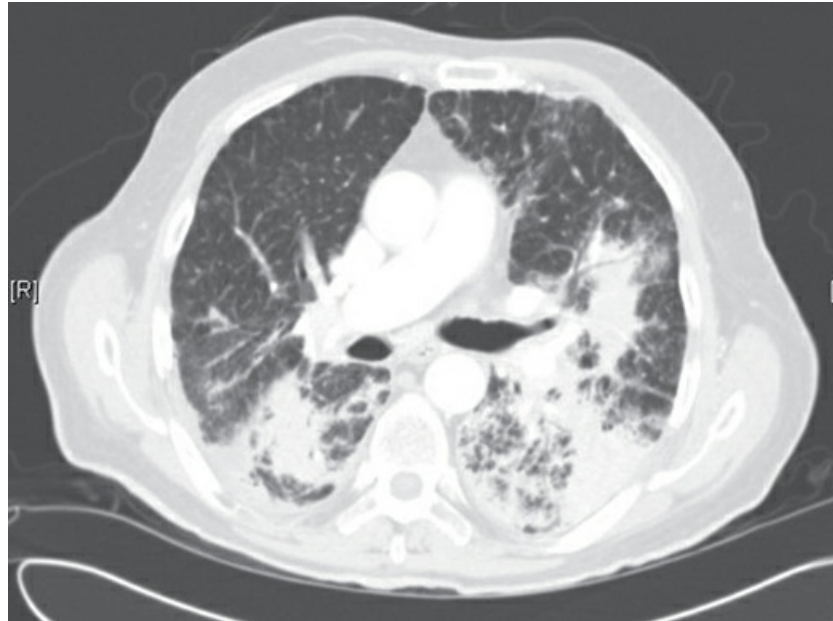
Chest CT scan demonstrating patchy alveolar opacities in a patient with cryptogenic organizing pneumonia.
